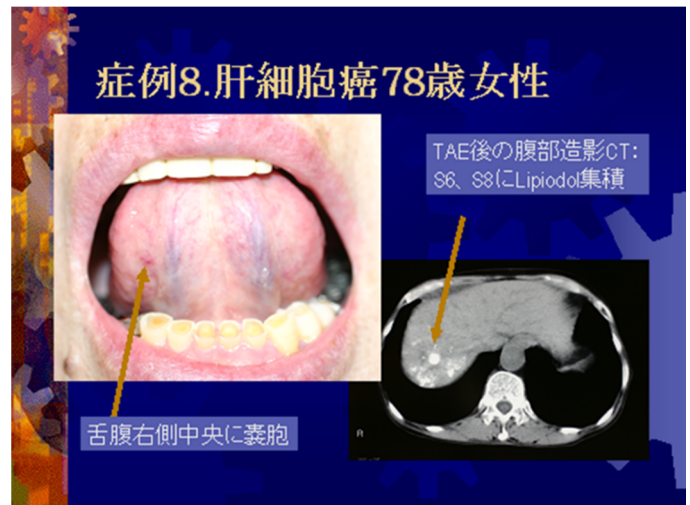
Pictures of tongue and magnetic resonance image, cited from “*Tongue inspection and imaging diagnosis*,” *Oriental Medicine Journal of Acupuncture & Moxibustion vol. 1*.
